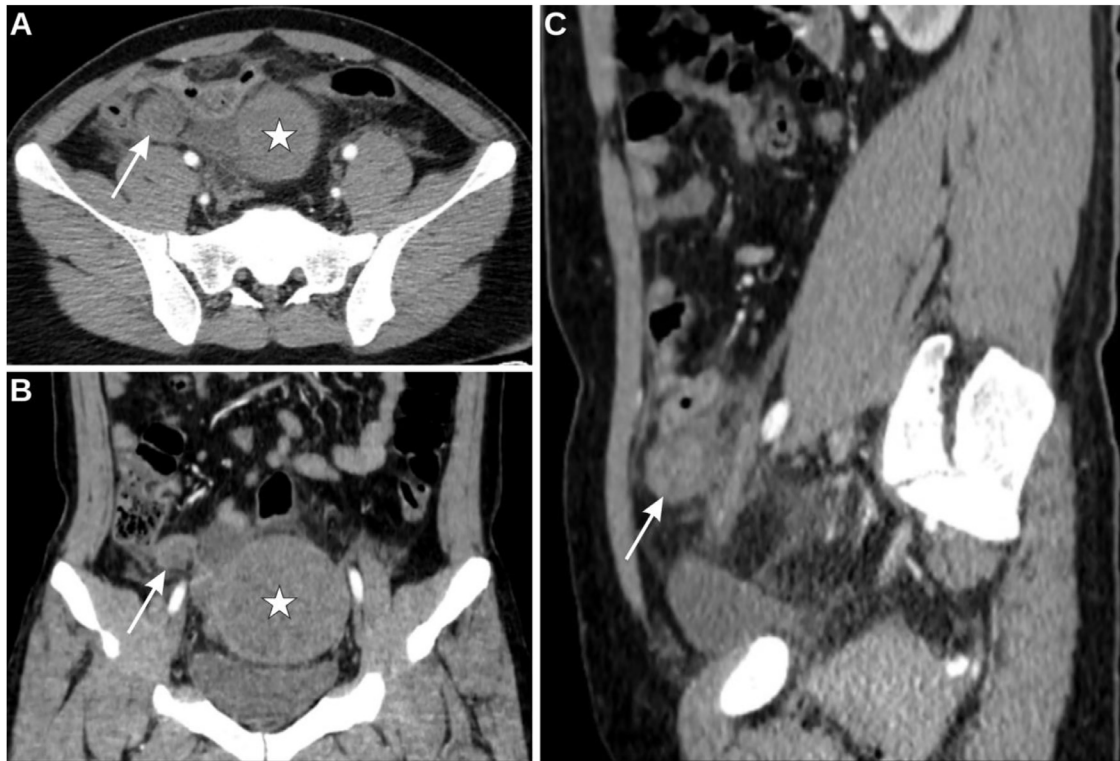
Multiplanar reconstruction (MPR) of arterial phase CT images. (A) Axial, (B) coronal, and (C) sagittal views reveal a hypogastric soft-tissue mass (star) with a twisted pedicle (white arrows), forming a “whirl sign” consistent with spermatic cord torsion. Surrounding fat stranding is evident.
